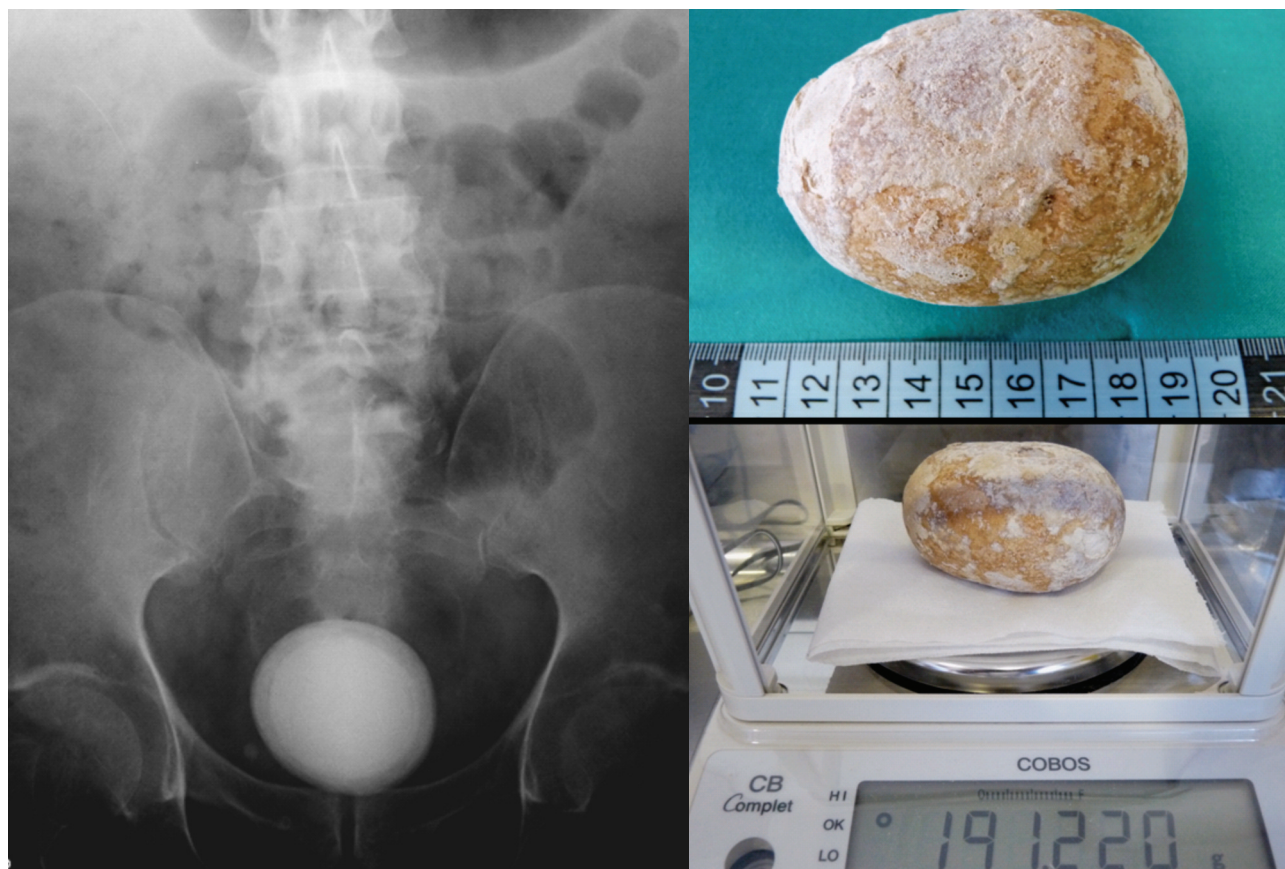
Left: abdominal x-ray showing a rounded mass of calcium density in the hypogastrium. Right: macroscopic image of the giant bladder stone removed during surgery.
